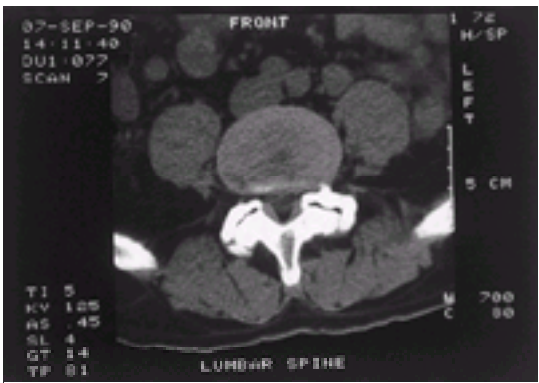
CT scan through the L4/5 disc space; note the irregular facet joints particularly on the left. The L5 nerve root was trapped between this hypertrophied facet joint posteriorly and the vertebral bodies and disc space anteriorly; this produces the 'lateral gutter syndrome'.
